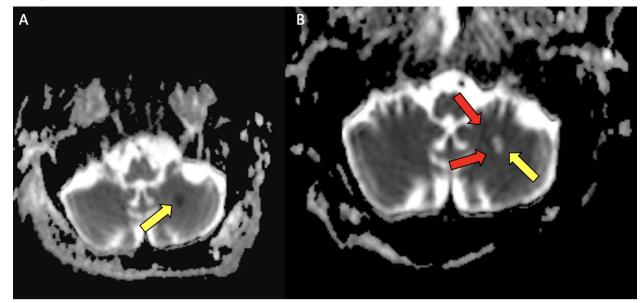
MRI ADC imaging of the brain at presentation (A) demonstrates area of restricted diffusion in the left cerebellar hemisphere (yellow arrow). MRI of the brain one month later (B) demonstrates stippled new areas of restricted diffusion (red arrows) adjacent to the original lesion (yellow arrow).
